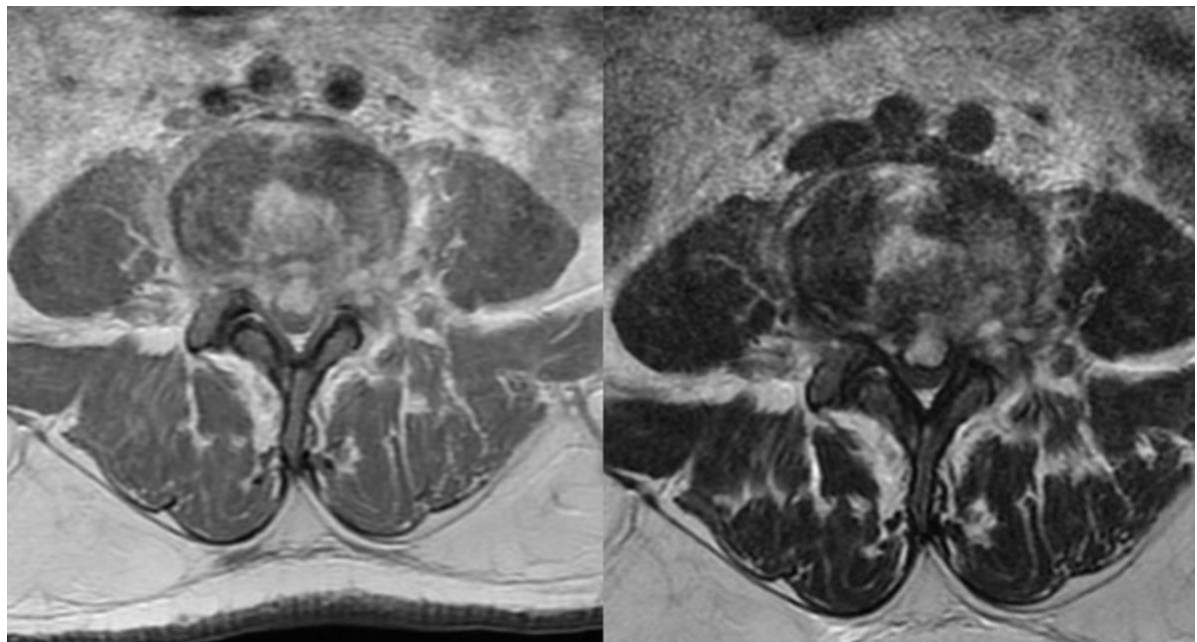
Pre-Operative MRI Lumbar T1 and T2 Axial. L4-L5 epidural abscess with canal stenosis and L4 vertebral body osteomyelitis.
